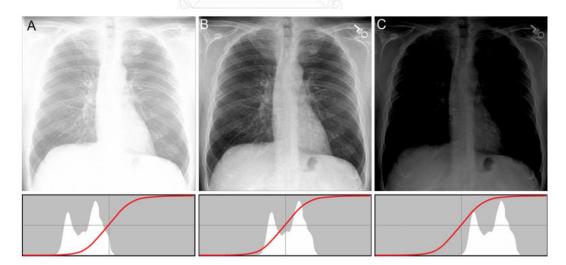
The responses of a screen-film detector with a fixed radiographic speed to (A) underexposure, (B) correct exposure and (C) overexposure. Underneath each image is a histogram representing the intensity of X-rays transmitted through the patient. The x-axis represents transmitted exposure intensity and the y-axis represents magnitude. The s-shape line is the characteristic curve that translates exposure intensity into optical density on the processed film. Note that this curve does not change position along the exposure axis [12].
